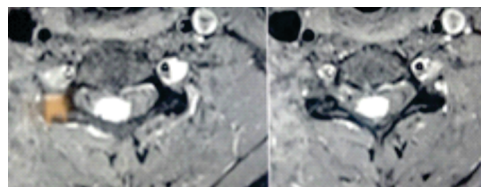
Preoperative MRI Axial with Contrast
